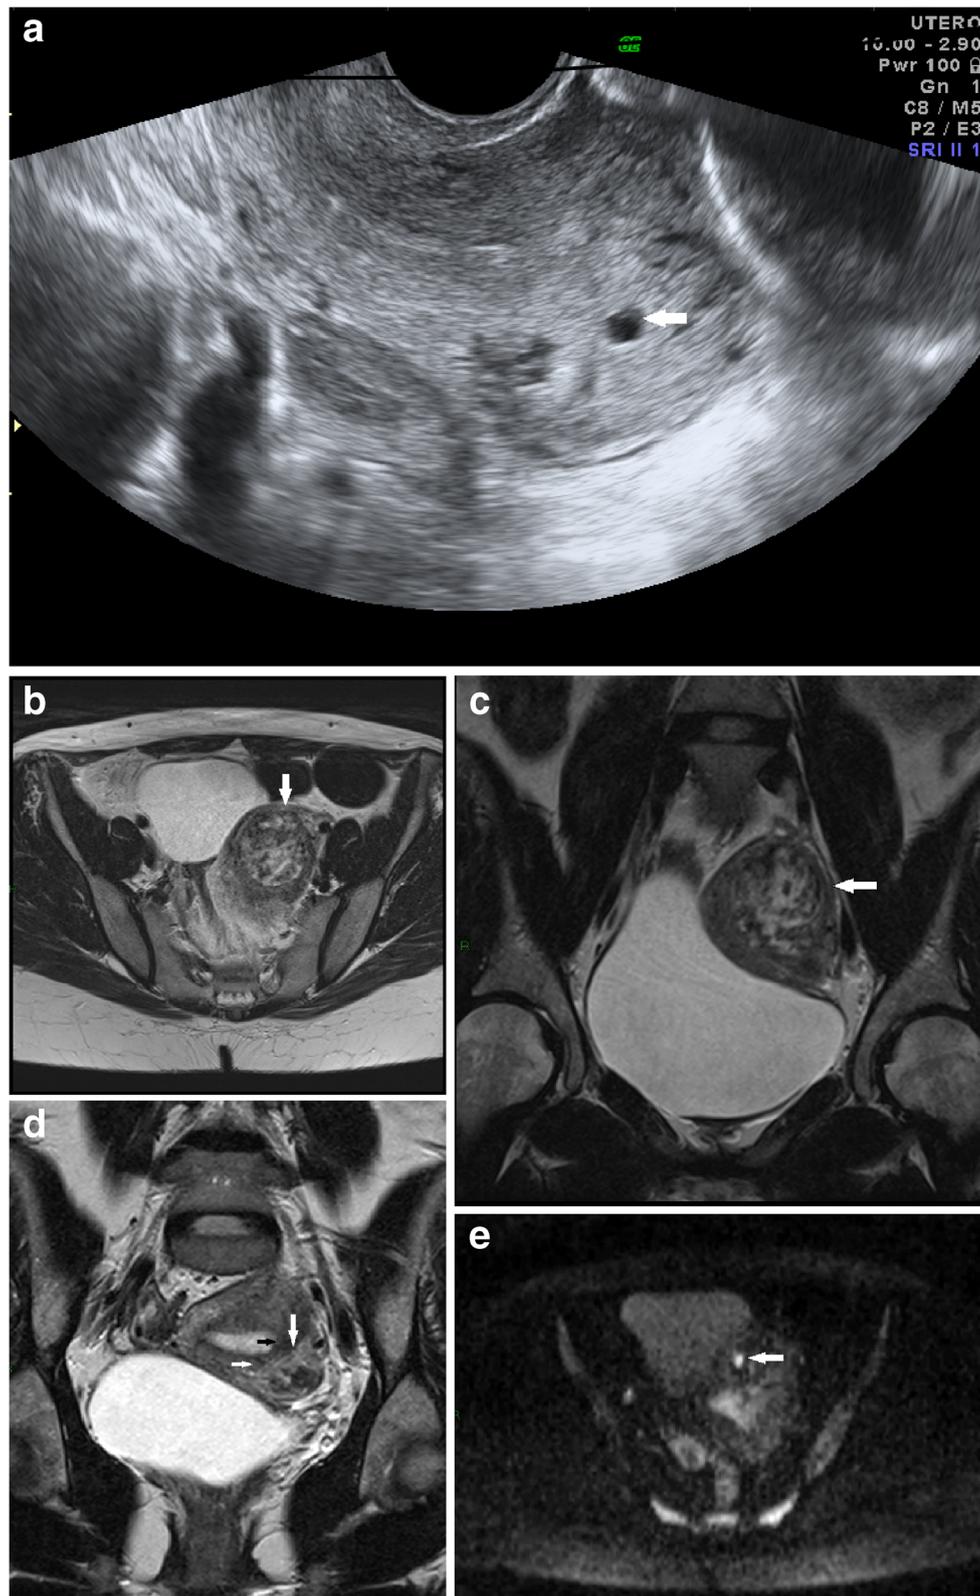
Caesarean scar pregnancy in a 39-year-old woman at 7 weeks' gestation. Transvaginal US (A) showed the presence of a dysmorphic gestational sac (GS) (39 × 26 mm) (white arrow), containing a fetal pole without cardiac activity, in the cervical region. Axial T1- (B), sagittal T2- (C) and axial T2-weighted imaging (WI) (D) MR scans showed a GS-like
